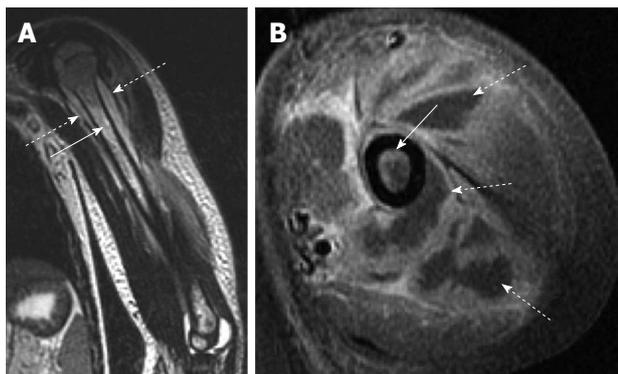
Acute osteomyelitis secondary to methicillin-resistant *Staphylococcus aureus* infection. A: Coronal T2-weighted image of the left humerus shows bone marrow edema (solid arrow) as well as a periosteal fluid collection (dashed arrow) consistent with periosteal abscess; B: Axial T1-weighted post-contrast image shows both enhancement of the bone marrow (solid arrow) as well as extensive periosteal and soft tissue abscess formation (dashed arrows) which is characteristic of methicillin-resistant *Staphylococcus aureus* infection.
